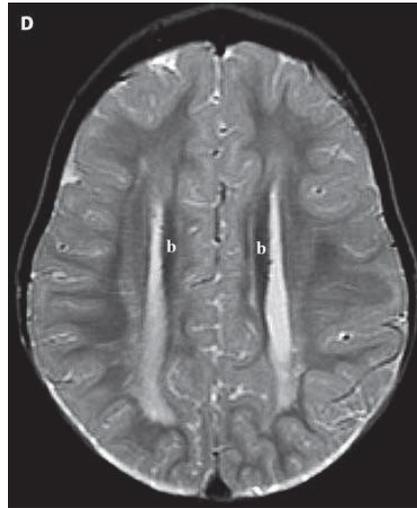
T2-weighted image on the axial plane showing the Probst beams, more hypointense than the remaining white matter. Barkovich Pediatric neuroimaging.
